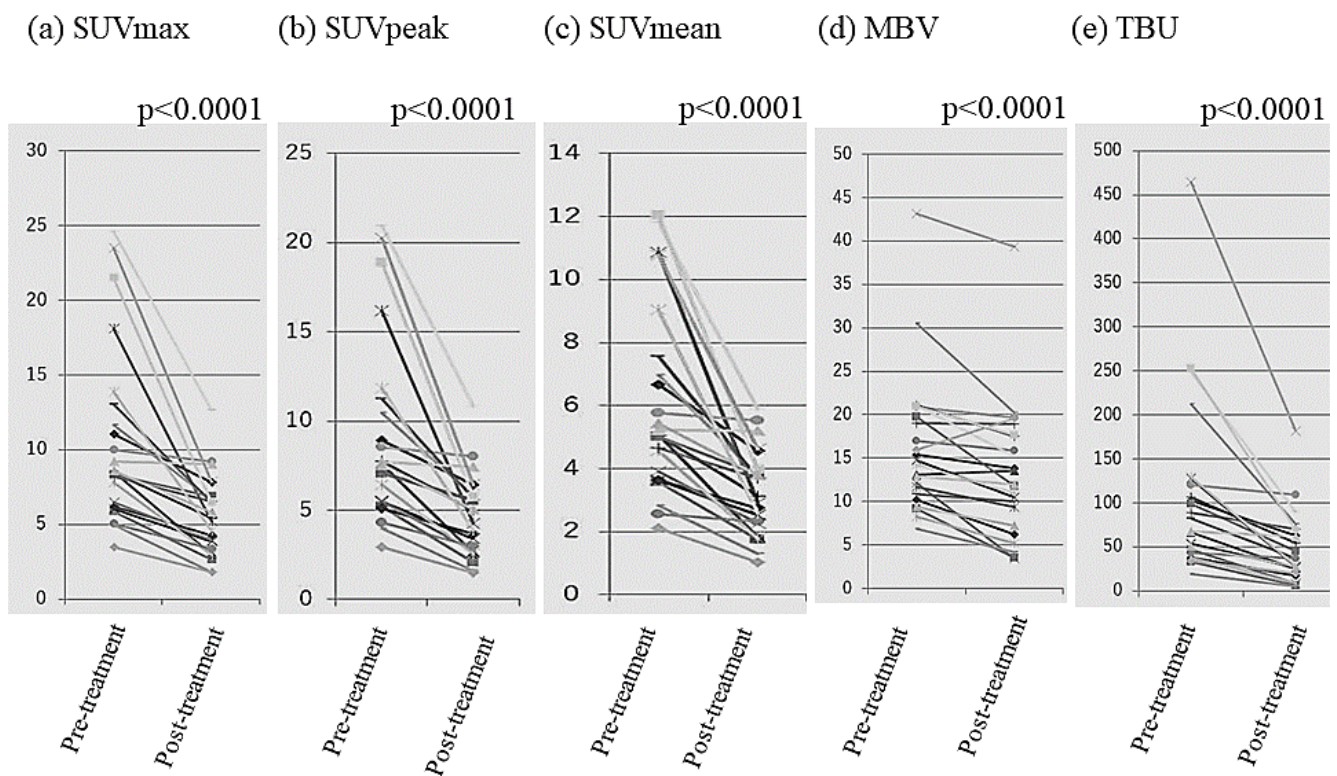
Transition line graphs showing changes in (a) harmonized SUVmax, (b) harmonized SUVpeak, (c) harmonized SUVmean, (d) harmonized MBV, and (e) harmonized TBU between the first and second SPECT/CT examinations in the 23 responder lesions.
